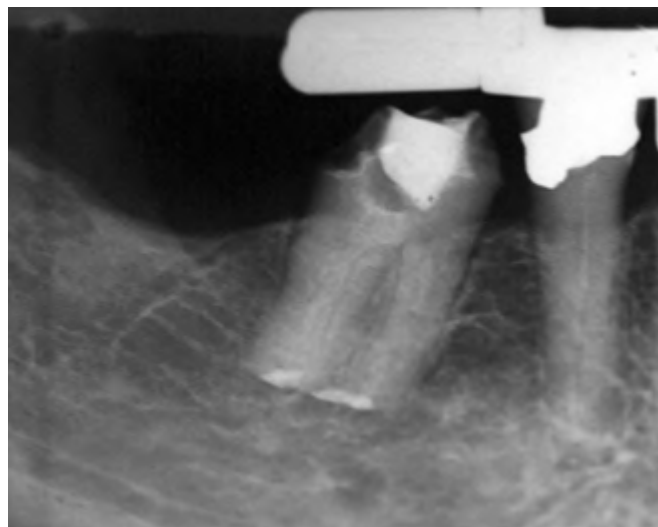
Preoperative periapical radiograph of teeth #28 and 30. There are distal caries noted for both teeth. If the teeth were to be salvaged, endodontics, clinical crown lengthening, post and cores, and new crown restorations would be indicated.
